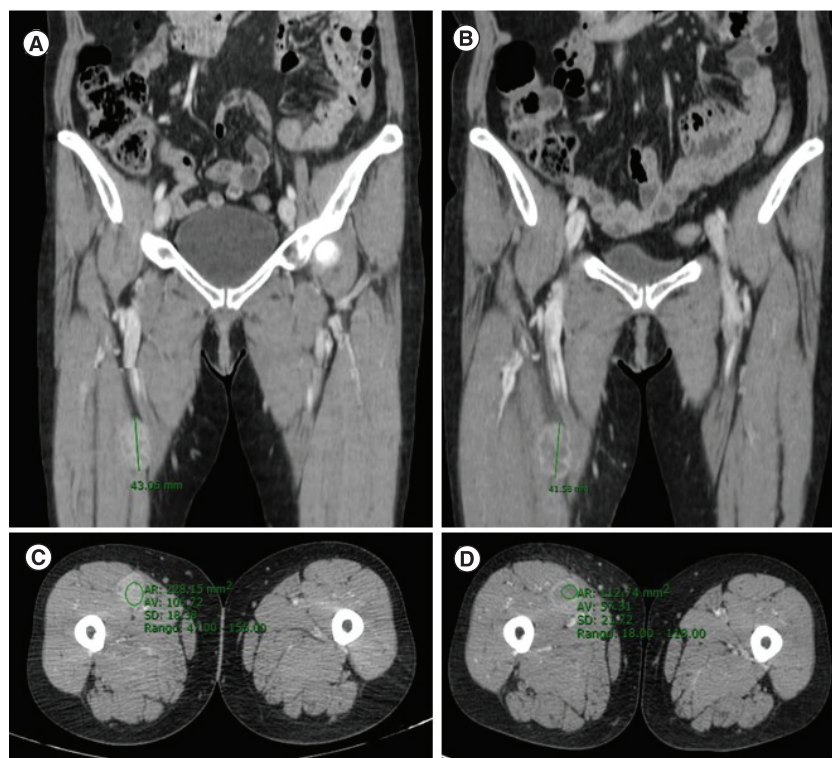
Coronal computerized tomography scan images of a soft-part nodule in the right thigh of a patient with metastatic leiomyosarcoma. (A) August 2018 at baseline. (B) January 2019 after 3 months' therapy with trabectedin. The lesion was stable according to Response Evaluation Criteria in Solid Tumors 1.1 (reduction of 3.4%), but a clear reduction in tumor density can be observed. Axial CT scan images of the same lesion with density measurements (HU) at (C) baseline (106 HU) and (D) after 3 months' therapy with trabectedin (57 HU). The 46% reduction in density corresponds to a partial response by Choi criteria.
